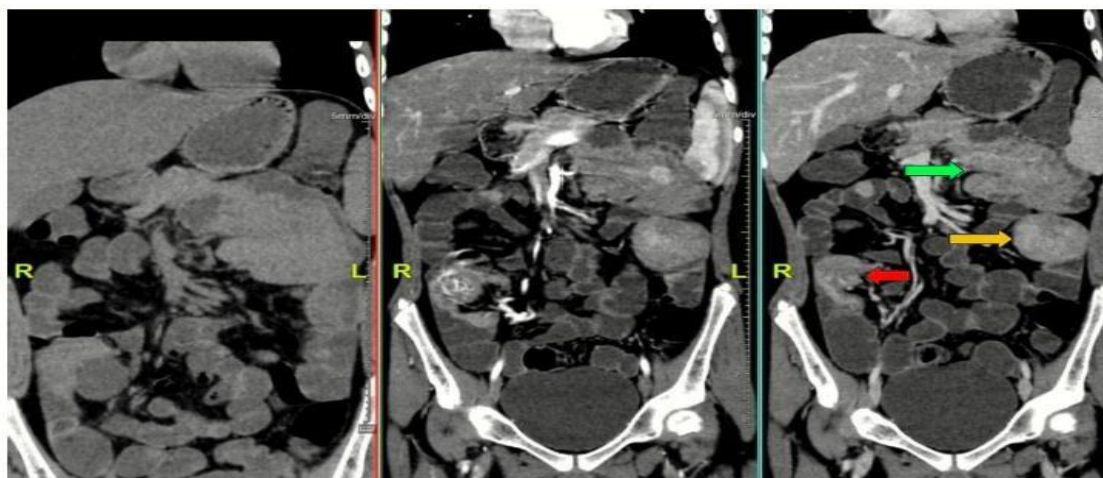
Coronal Plain and post contrast CT images of the abdomen showing bowel within bowel appearance at the ileocecal junction (red arrow) and at the jejuno-jejunal region in left hypochondrium (yellow arrow). Multiple enhancing polyps can be seen in the jejunal loops (green arrow).
